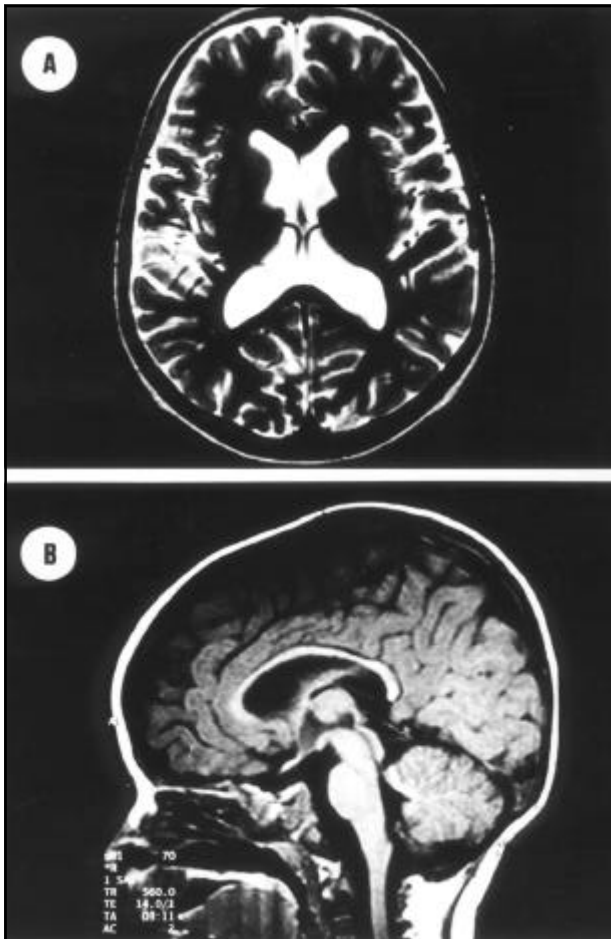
A) T1 weighted axial MRI image of patient 2 showing large global lateral ventricles. B) T1 weighted midsagittal MRI image shows hypoplasia of the corpus callosum and persistence of the cavum velum interpositum.
